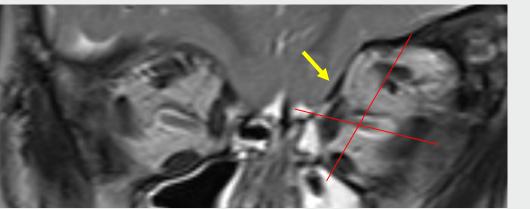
Patient with plagiocephaly with right head tilt, left hypertropia and left inferior oblique overaction was diagnosed with left superior oblique palsy. MRI shows anisotropic atrophic left SO tendon (yellow arrow), and significantly excyclo-rotated left orbit
